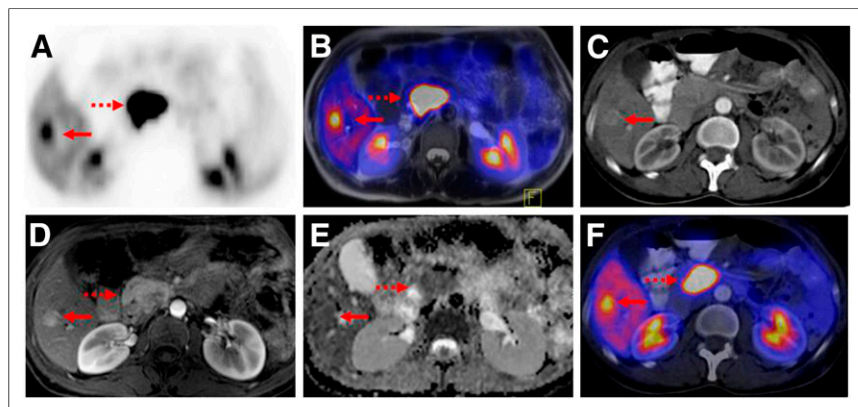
Simultaneously acquired ^{68}Ga -DOTATOC PET/CT and PET/MR images in 41-year-old patient with biopsy-proven NET of pancreas (dotted arrow) and liver metastasis in lateral fifth segment of liver (solid arrow) are shown. PET part of PET/MR (A), PET/MR (B), and PET/CT (F) images show intense focal ^{68}Ga -DOTATOC uptake in pancreatic head and location of liver metastasis. In corresponding CT scan, liver metastasis can be clearly identified, with its peripheral arterial contrast enhancement (C), whereas identification of primary tumor in pancreatic head is difficult. In corresponding MR images, there is intense arterial hyperperfusion of liver metastasis and pancreatic head in dynamic GRE sequence (D) and low apparent diffusion coefficient values both in pancreatic head and in location of liver metastasis, indicating diffusion restriction (E).
